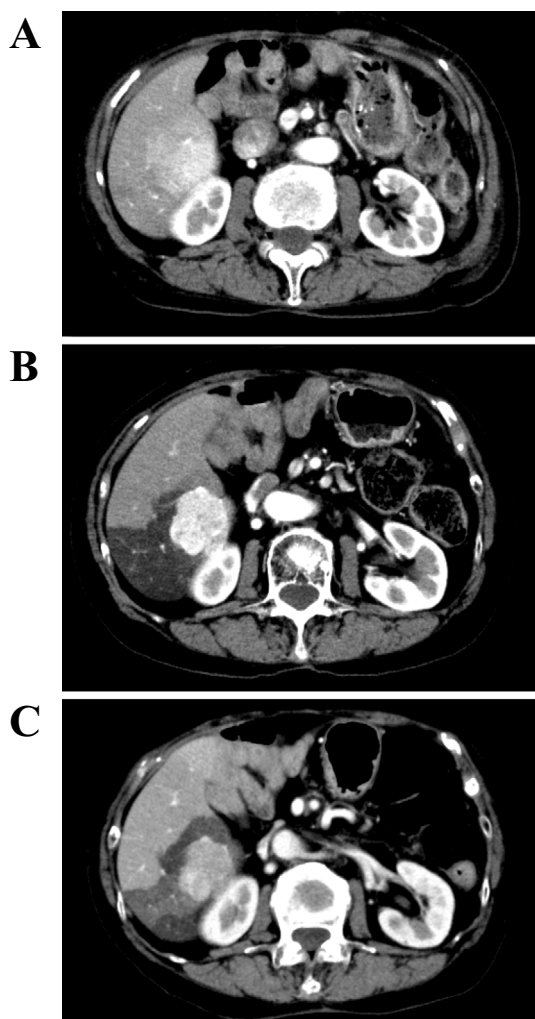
Abdominal computed tomography imaging of the liver: (A) before (Day 0), (B) three months after (Day 98), and (C) six months after (Day 189) the administration of everolimus. The maximum diameter of the S6 tumor was 45 mm on day 0 (A), 39 mm on day 98 (B), and 39 mm on day 189 (C).
